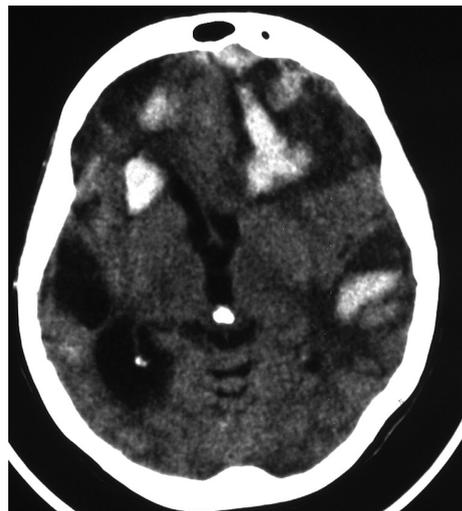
CT showing multiple parenchymal brain hemorrhages in patient with infective endocarditis and necrotizing angiitis of central nervous system.
